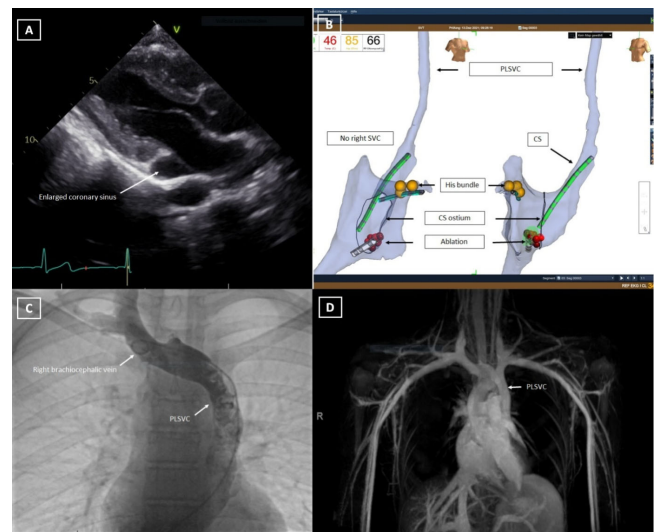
Enlarged coronary sinus (CS) in the parasternal long axis view by transthoracic echocardiography (A); persistent left superior vena cava (PLSVC) and enlarged CS ostium (dark oval circle) by 3D-electroanatomic mapping system (B), selective angiography (C) and magnetic resonance imaging of the thorax (D).
